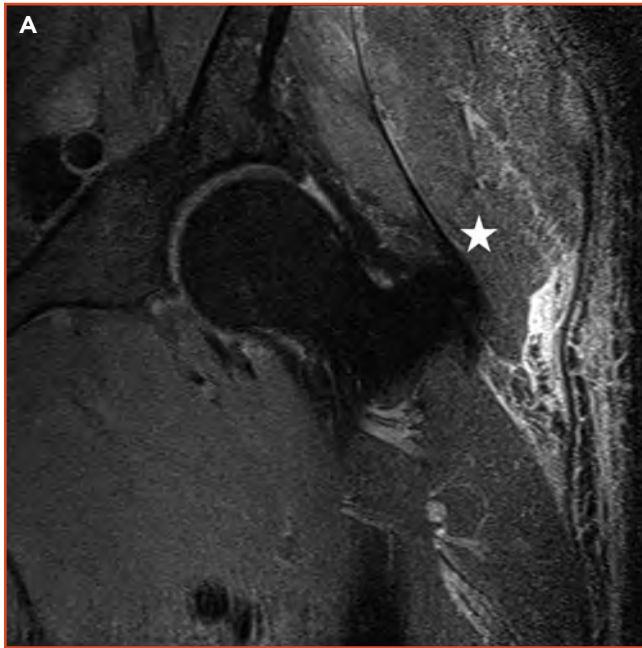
A) Coronal and B) sagittal magnetic resonance imaging of the left side of the hip, showing an intact gluteus tendon insertion (star) on the greater trochanter.
